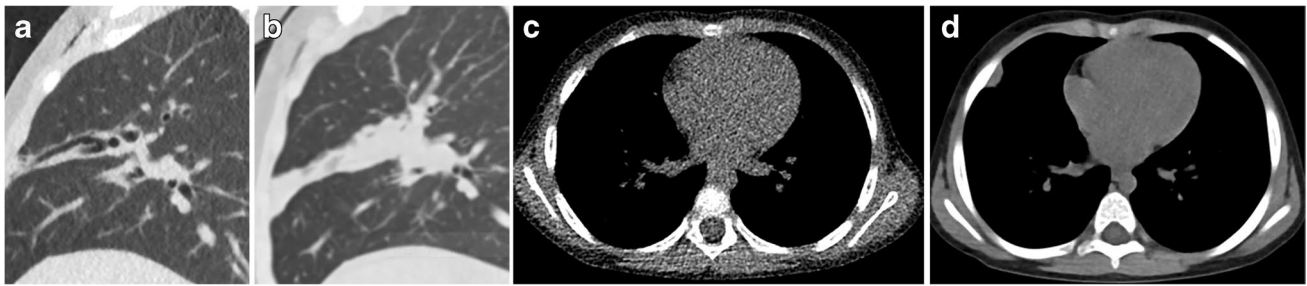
Photon-counting detector (PCD)-CT images in the same 6-year-old girl with cystic fibrosis as in Fig. 3. a–d Lung window images show comparable image quality, despite a 95% radiation dose reduction of the PCD-CT images (a, sagittal) from that of the conventional energy integrating detector (EID)-CT images (b, sagittal). The PCD-CT volumetric CT dose index (CTDI_{vol}) was 0.05 mGy and the effective dose was 0.09 mSv. The EID-CT CTDI_{vol} was
